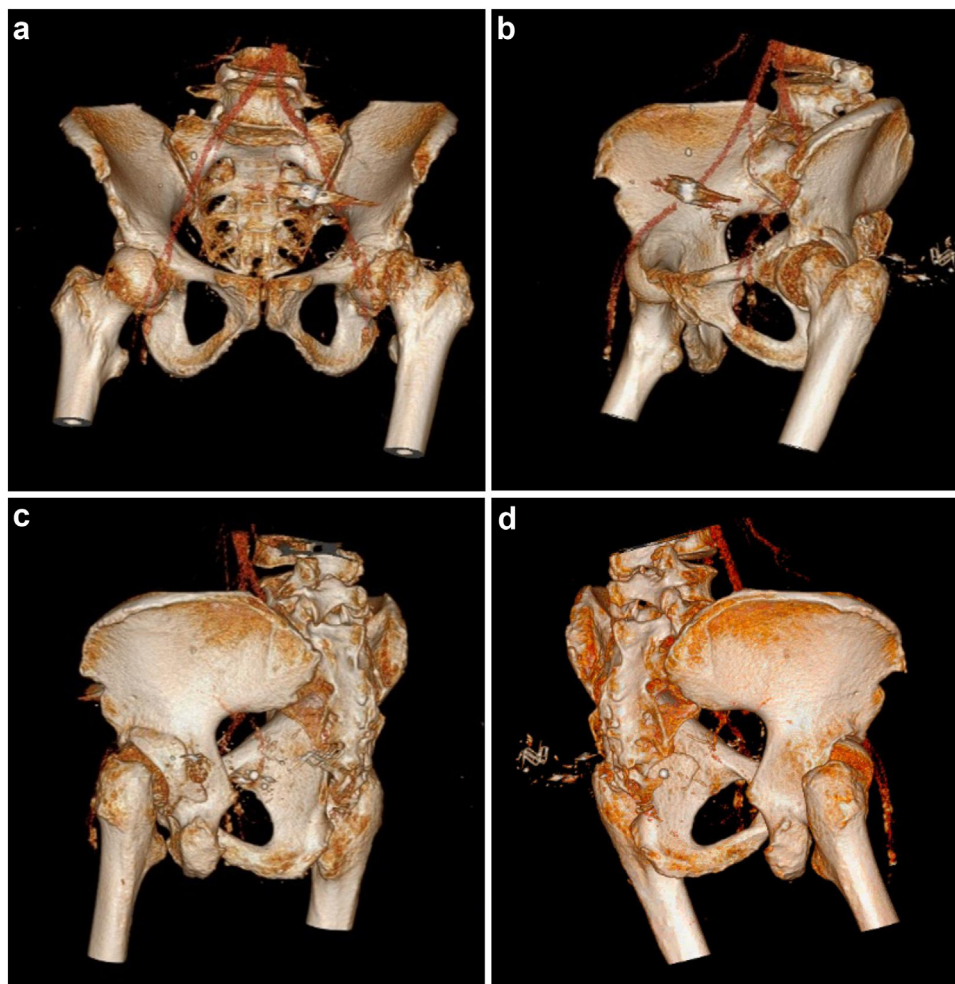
Three-dimensional CT reconstruction images were acquired to further characterize the femoral head and acetabular fracture fragments. These images demonstrate (a-c) fractures of the posterior wall and (d) fracture through the quadrilateral plate.
